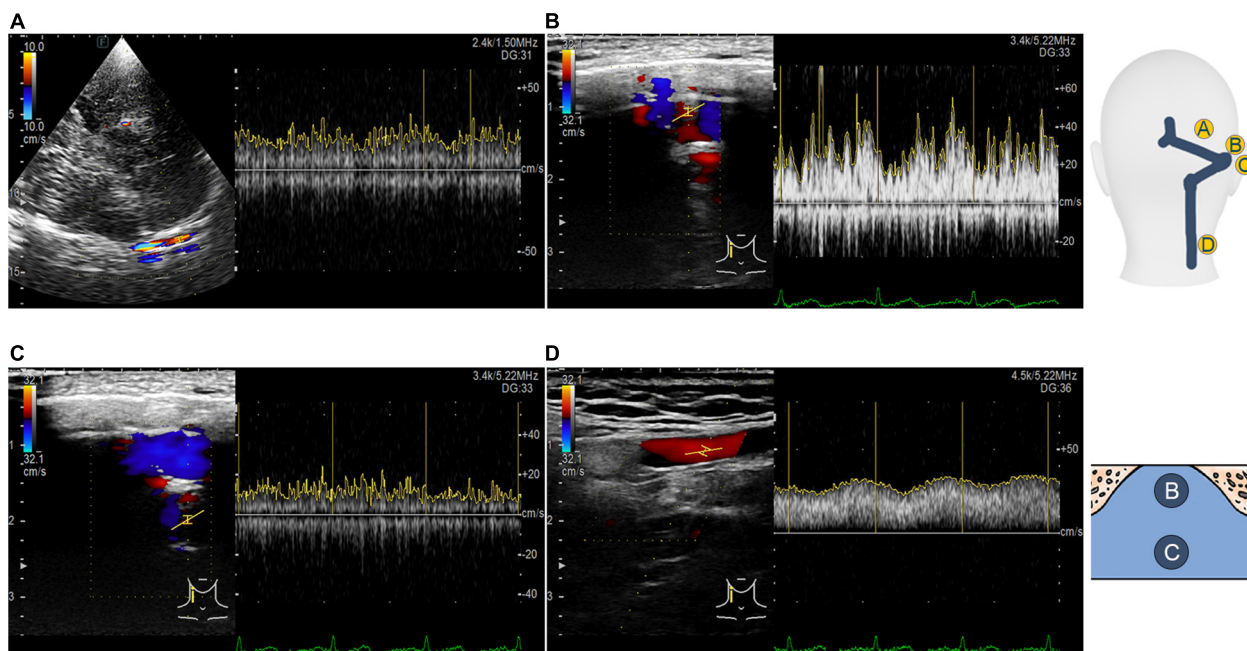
Transcranial, retroauricular, and cervical color-coded Doppler methods to assess hydroacoustics of the transverse-sigmoid sinus system. (A) Visualization and velocity spectrum of the proximal transverse sinus flow using the TCCD. (B) Visualization and velocity spectrum of the diverticular flow using the RCCD. (C) Visualization and velocity spectrum of the mainstream intrasinus flow using the RCCD. (D) Visualization and velocity spectrum of the upper internal jugular flow using the RCCD.
